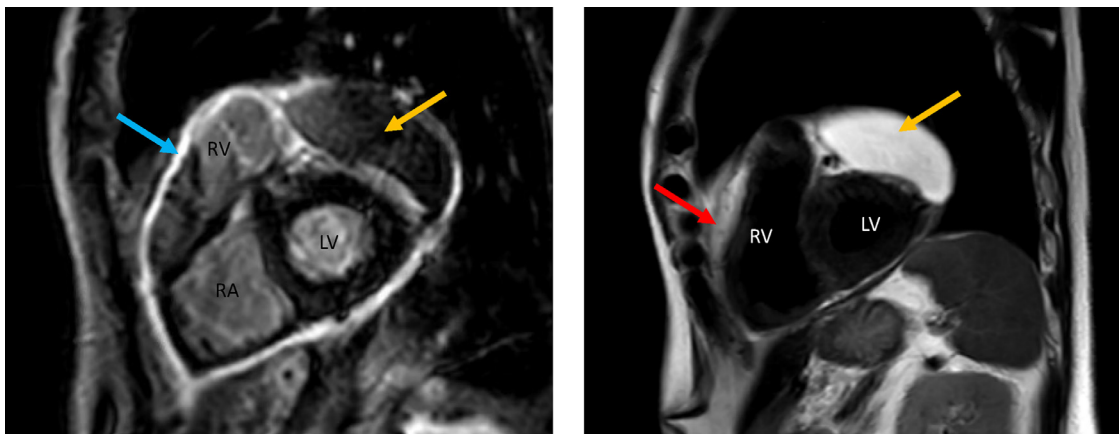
Cardiac magnetic resonance imaging showing a pericardial mass (orange arrow) associated with signs of pericardial inflammation as demonstrated on short-axis views by severe delayed enhancement (blue arrow) and pericardial edema on T2 short-tau inversion recovery weighted imaging (red arrow). LV = left ventricle; RA = right atrium; RV = right ventricle.
